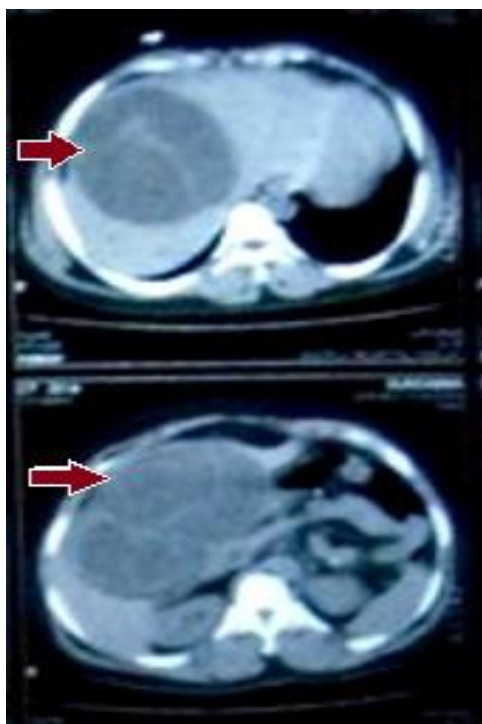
CT showing large cyst in the right and left lobes of liver with daughter cysts(arrow)
